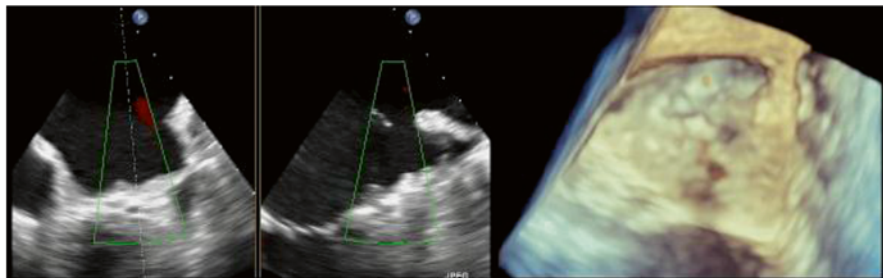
Appearances of the closed ostium of the LAA once Lariat loop has been tightened, prior to release. The occlusion should approximate the ostium, and assessment with colour Doppler should be performed to assess for residual flow. Images courtesy of Dr R. Lee, San Francisco
